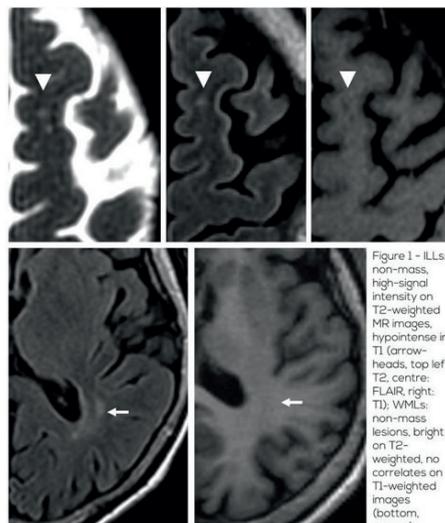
Infarct like lesions (ILLs) and white matter lesions (WMLs) appearance on brain MRI.
